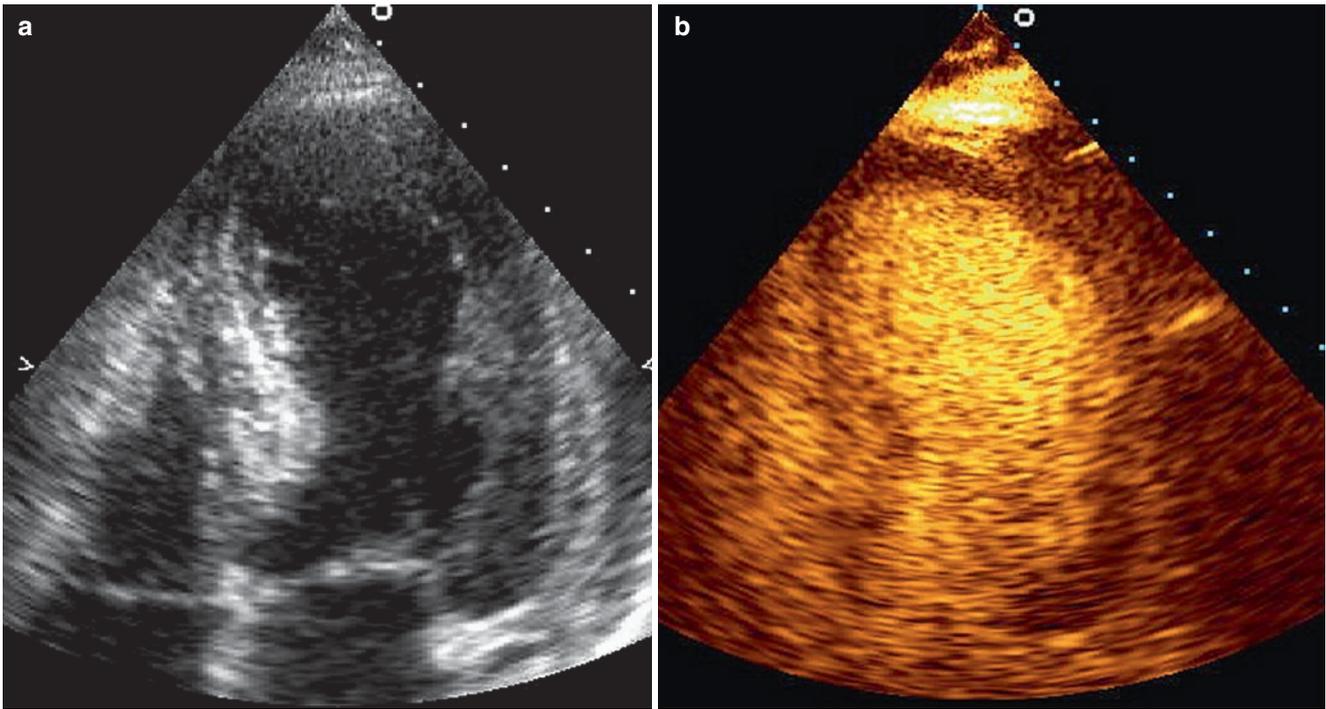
Systolic frames from apical 4-chamber projections in a patient with Tako-Tsubo cardiomyopathy. On the *left panel*, gray-scale imaging shows apical ballooning. On the *right panel*, contrast study a few seconds later demonstrates better the apical aneurysm
